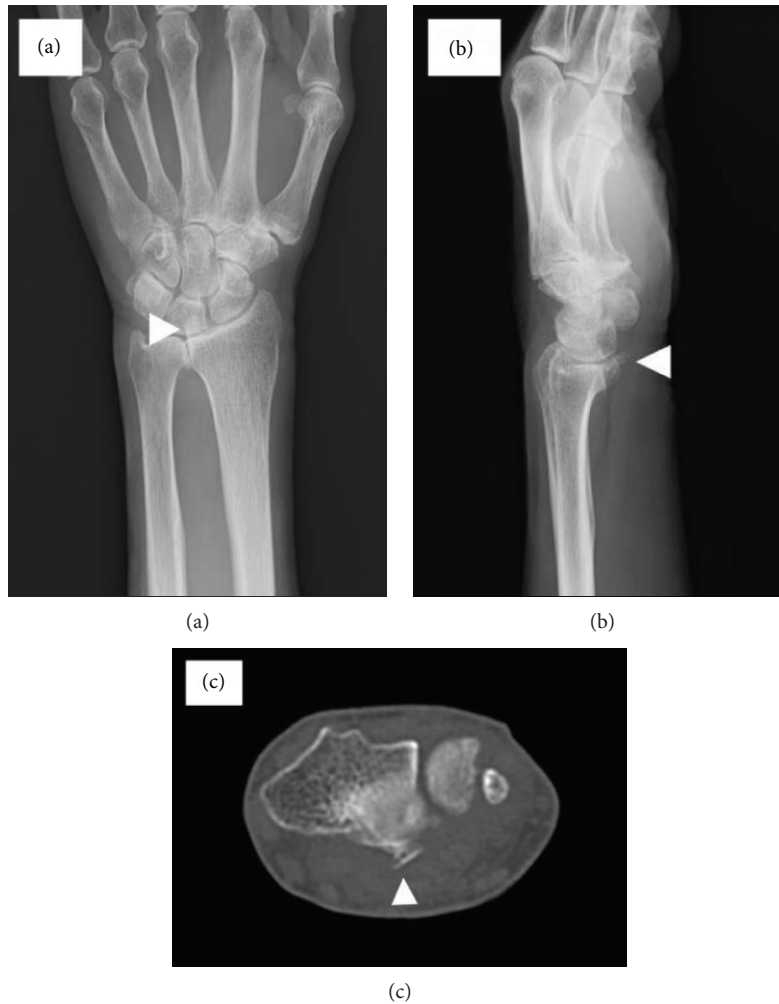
Clinical examination. (a) Bony spur on the anterior-posterior plain radiograph of the wrist joint (white arrowhead). (b) Bony spur on the lateral plain radiograph of the wrist joint (white arrowhead). (c) Bony spur on computed tomography (white arrowhead).
